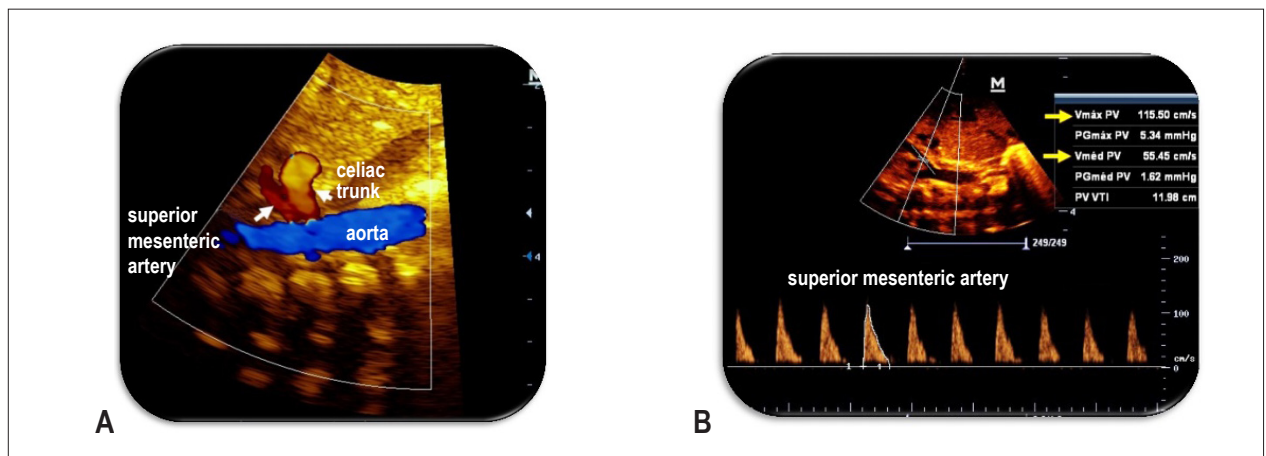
A: Blood flow in abdominal, superior mesenteric aorta and celiac trunk detected on Doppler color flow mapping; B: Blood flow in superior mesenteric artery detected on pulsed Doppler, obtained after correction of the angle between the flow of said artery and the ultrasound beam. peak systolic flow velocity of 115,5 cm/s, end diastolic flow velocity of 0 cm/s and mid-velocity of 55,45 cm/s, resulting in a pulsatility index of 2.08. Newborn with gestational age of 28 weeks and 5 days, with a 2.2 mm ductus arteriosus; examined with 14 hours of life. Source: Personal archive of author AMRS.
